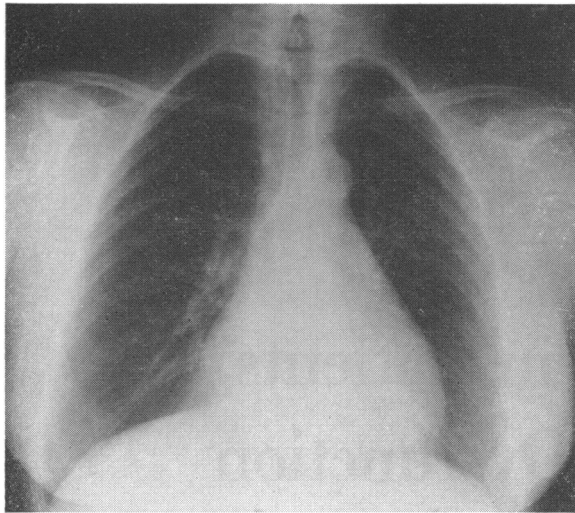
Chest radiograph of first patient taken at time of admission to hospital.
